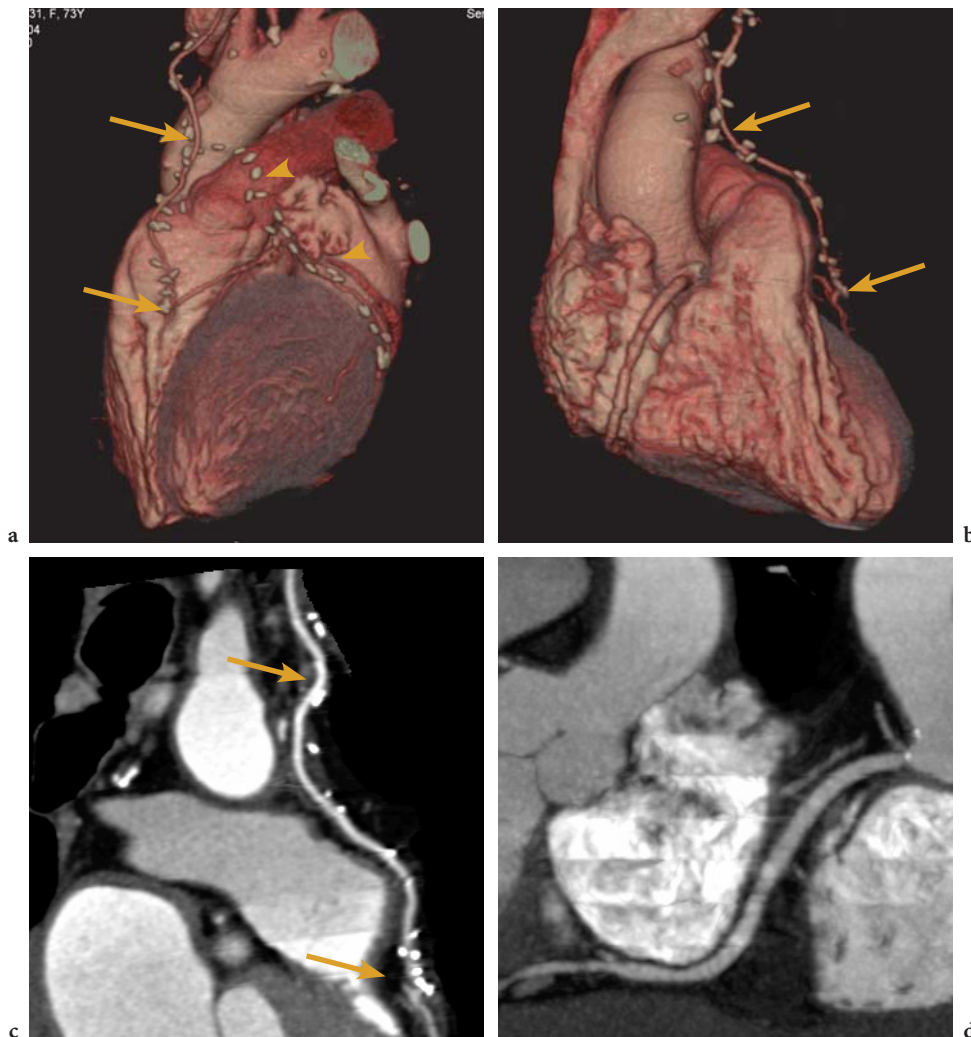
16-slice CT examination of a 74-year-old female patient with CABG procedure with IMA graft onto the LAD and a radial artery graft onto the CX. No venous graft material was available due to venous stripping surgery for treatment of chronic venous insufficiency. The patient presented for a follow-up examination for the CABG procedure 6 months earlier. The IMA graft is patent with no signs of stenosis in its entire course (a–c, arrows), whereas the radial graft is totally occluded (a, arrowheads), a common complication for this particular graft type. The dominant RCA reveals no pathology (b, d)
